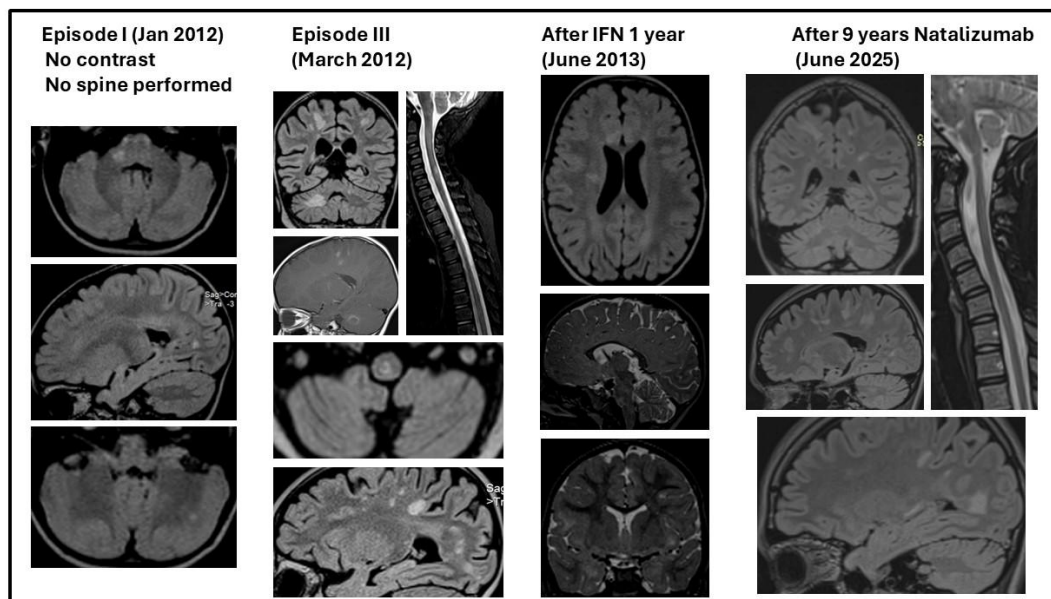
MRI at onset and in evolution.
